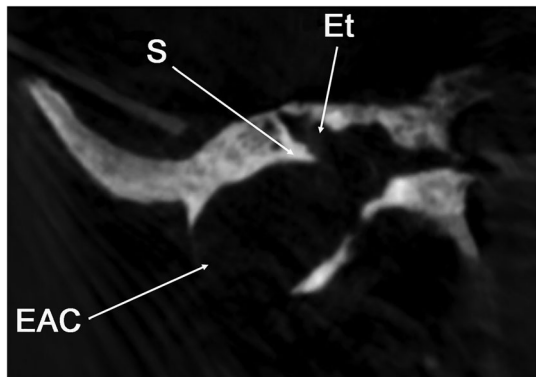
Coronal computed tomography (CT) of left temporal bone depict widening of the external acoustic canal (EAC), with scalloped and well-defined contours. Et, epitympanum; S, scutum
